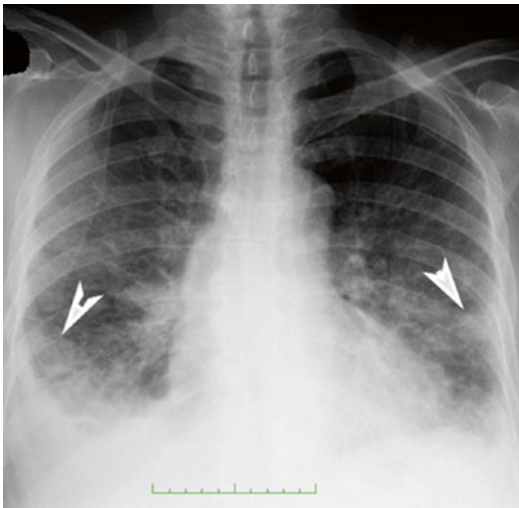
Chest radiograph shows peripheral pulmonary infiltrates (*arrows*) associated with pleural effusion
